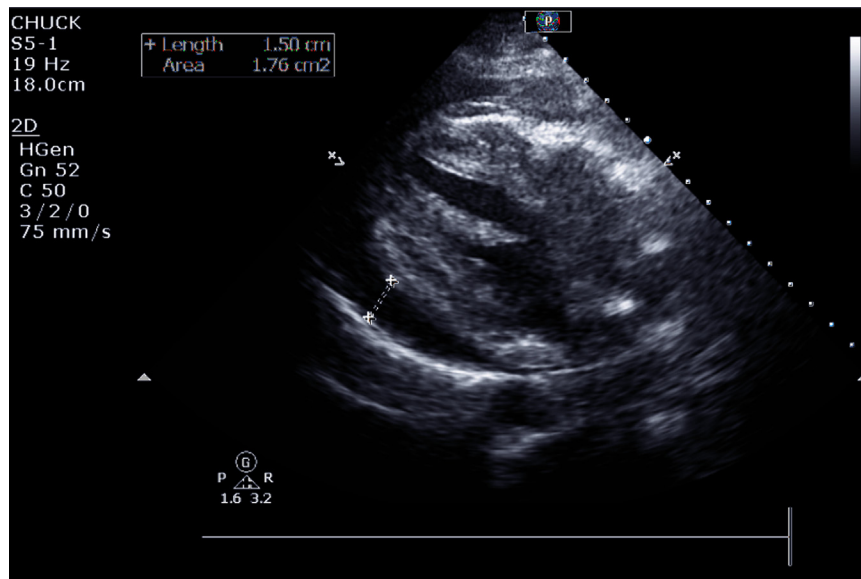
Transthoracic echocardiogram revealing pericardial effusion. White line marks width of pericardial effusion.
